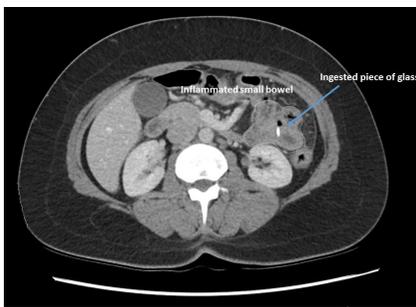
Preoperative CT imaging of small bowel perforation resulting from foreign body ingestion. Preoperative CT evaluation of the patient's abdomen noted a small pocket of mesenteric free air, inflamed segment adjacent to a loop of jejunum and a small radiopaque intraluminal object.
